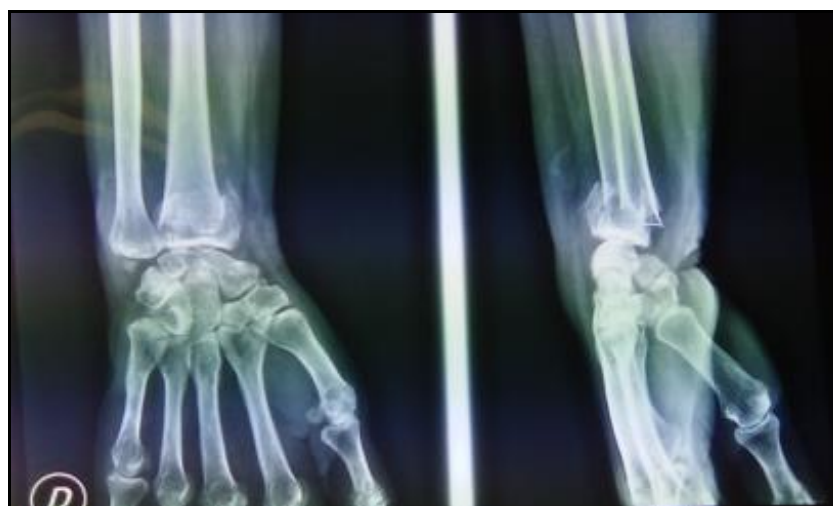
Wrist X-ray showing a posteriorly tilted right distal radius articular fracture in a 50-year-old female patient.
